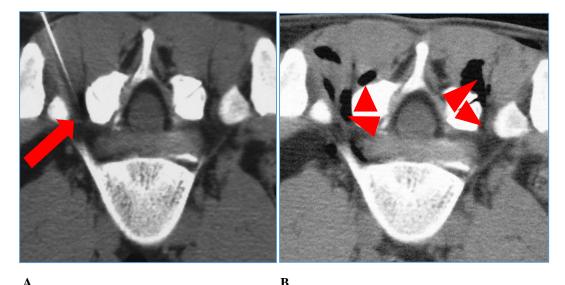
A) correct positioning of the needle at the level of the periganglionic region (arrow); B) CT control of the distribution of the oxygen-ozone gas mixture at the level of the foraminal region (arrowheads) and in correspondence with the articular masses (arrowheads).
